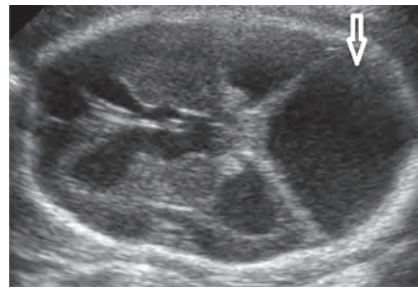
Cranial sonography shows cystic dilatation of the posterior fossa (white arrow) with enlargement of the posterior fossa.
